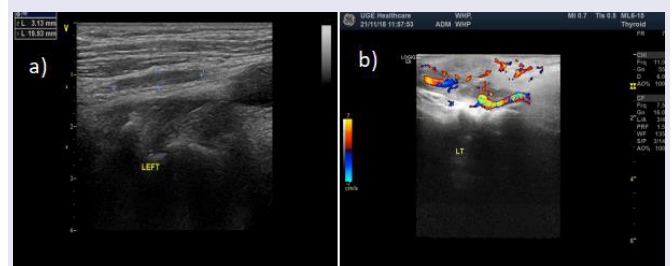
Cervical lymph node ultrasound showed that there were multiple low-echo nodes on both sides, with clear boundaries and capsula. The larger ones on the left and right sides were 20*3mm and 17*5mm respectively (a), And the blood flow signals in the nodules were not obvious; (b).
